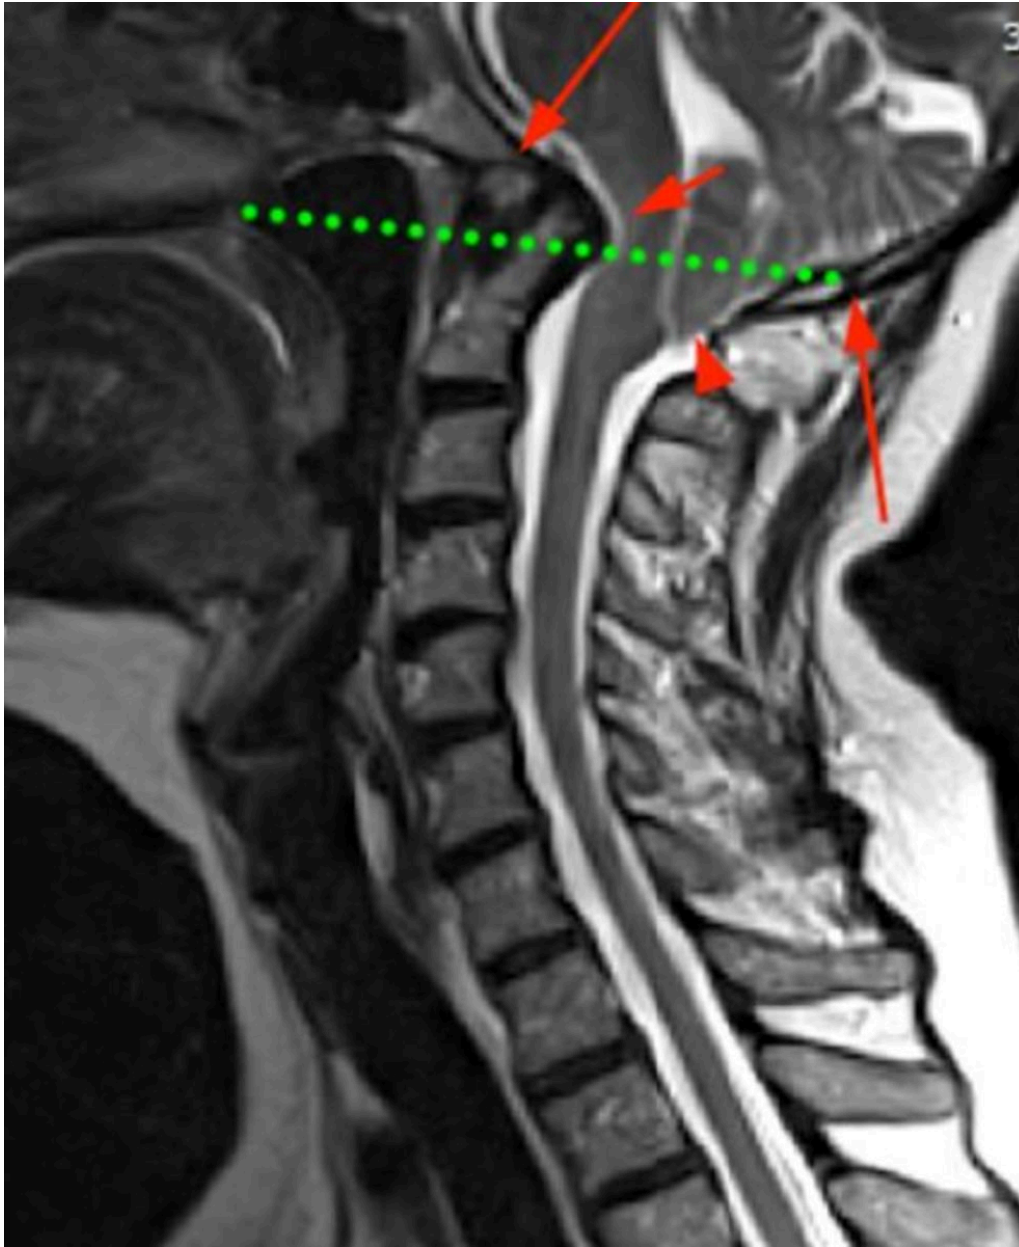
MRI congenital fusion of the occiput and c1 is present (long arrows) , known as atlantooccipital assimilation. The tip of the dens violates chamberlain line , showing basilar invagination with associated brain herniation (type 1 chiari).
